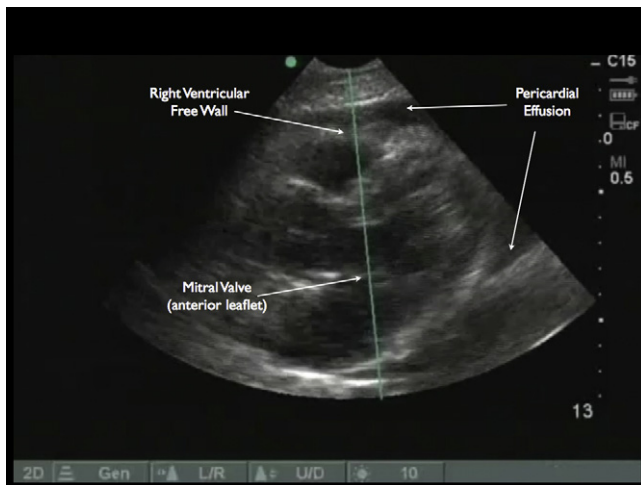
Parasternal long image using radiology orientation.
